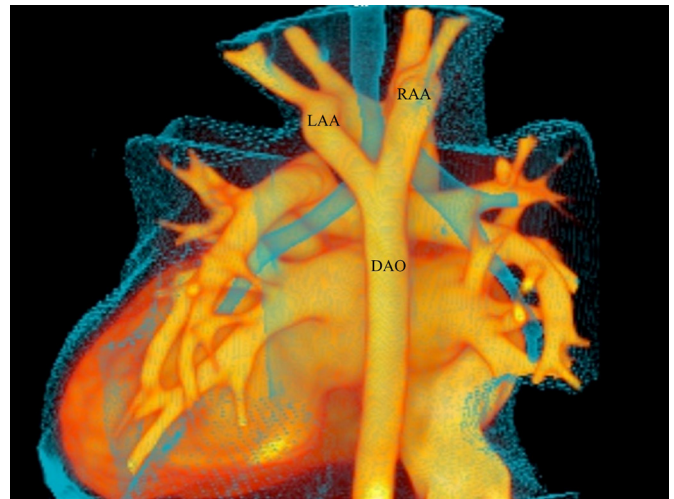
Computerized tomogram (CT) thorax showed the balanced aortic arch without narrowing of the trachea. DAO: descending aorta; RAA: right aortic arch; LAA: left aortic arch.
